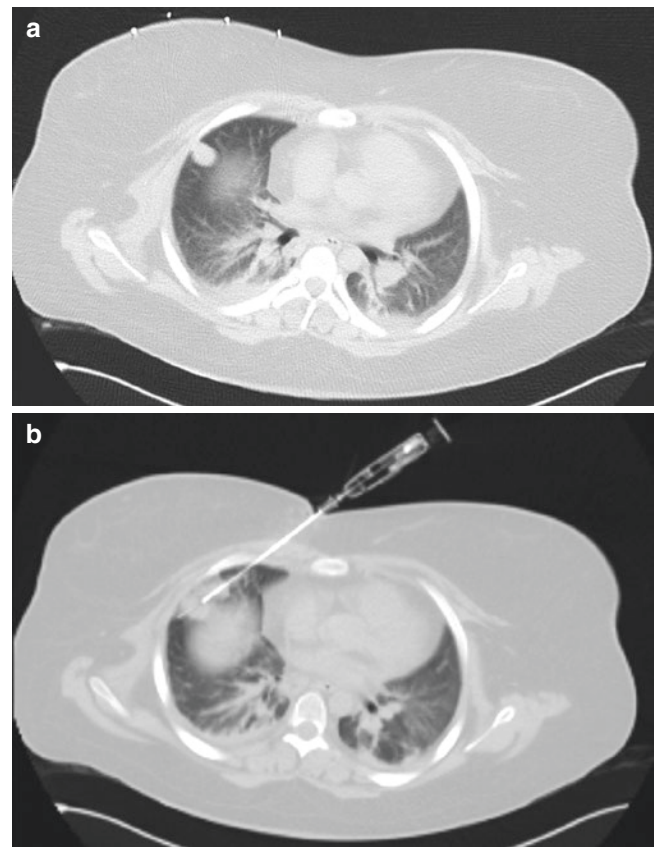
A 17-year-old female with a biopsy-proven Ewing sarcoma of the sacrum (not shown) and a suspicious pulmonary nodule. (a) A 19–20 gauge coaxial technique was used to biopsy the nodule under CT guidance (b). Pathology confirmed a metastasis of the Ewing sarcoma
